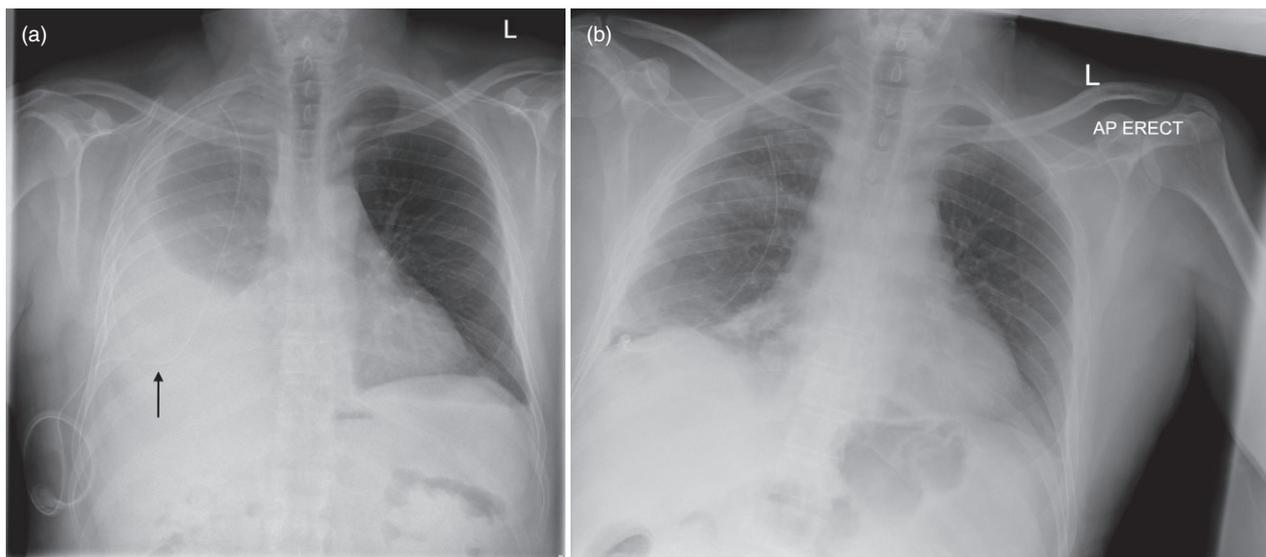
(a) Chest X-ray of a patient with indwelling pleural catheter *in situ* (arrow) for right-sided malignant pleural effusion who presented with symptomatic loculation (absent drainage, re-accumulation of effusion and recurrence of breathlessness). (b) Chest X-ray shows clearance of the pleural effusion after a single dose of tissue plasminogen activator.
